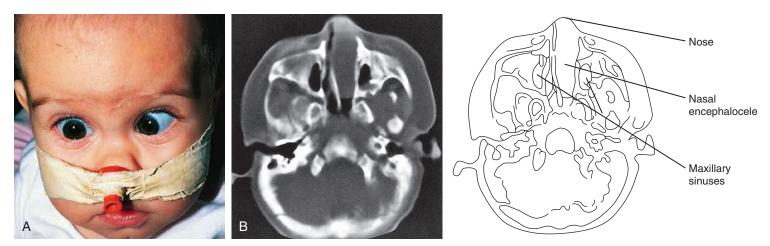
Nasal encephalocele. A, This normal-appearing infant had signs of severe nasal obstruction, necessitating insertion of a nasopharyngeal airway to relieve distress. B, A CT scan shows a large nasal mass lesion that fills one nostril and pushes the nasal septum into the other. This lesion proved to be an encephalocele extruding through a bony defect in the skull base (extrusion seen on another CT cut).
